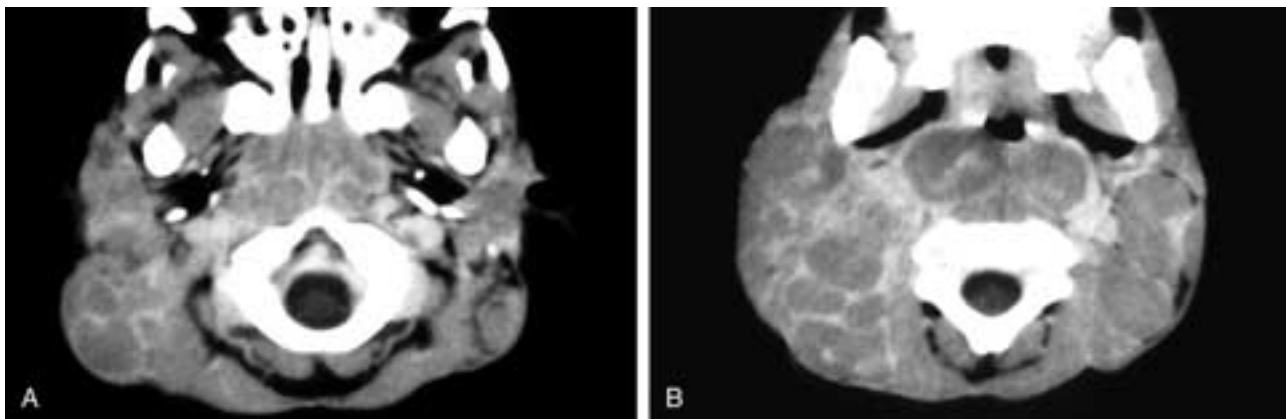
Axial CT scans from cranial (A) to caudal (B) show considerable enlargement of virtually every node in this 1-month-old infant. Note that the retropharyngeal nodes are also involved, and all of the nodes have a fairly low attenuation. In an older patient, this imaging appearance would suggest a lymphoma. However, in a patient this young, histiocytosis must be considered. This patient had histiocytosis.
